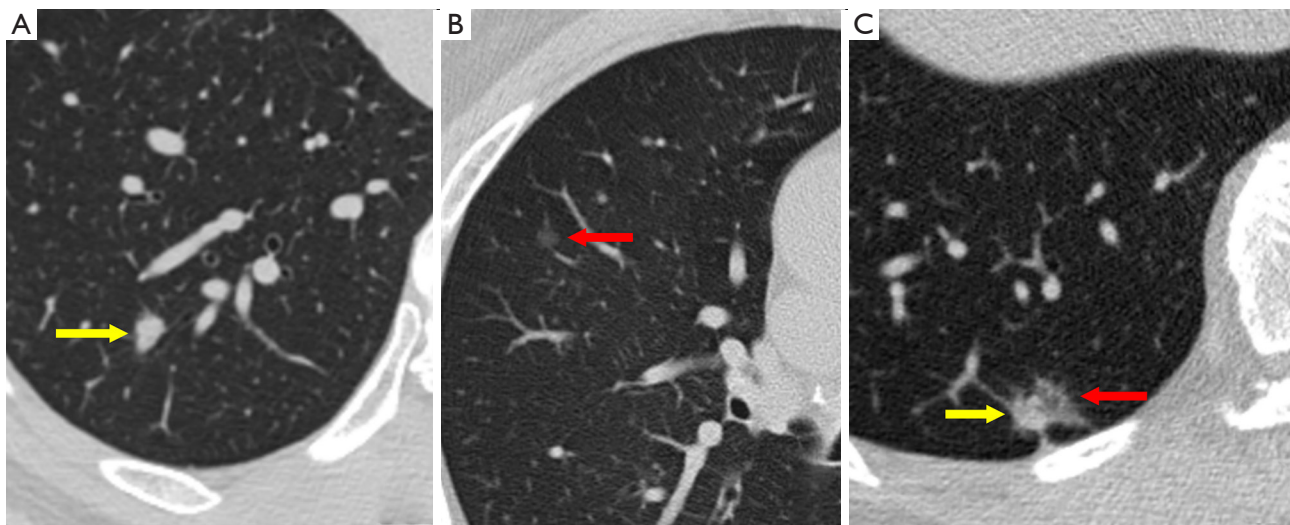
Axial CT images of pulmonary nodules. (A) Solid nodules appear as homogenous soft-tissue components (yellow arrow). (B) Ground-glass nodules represent regions of hazy attenuation in the lung, with preservation of bronchial and vascular margins (red arrow). (C) Part-solid nodules consist of both ground-glass (red arrow) and solid soft-tissue (yellow arrow) attenuation components. CT, computed tomography.
